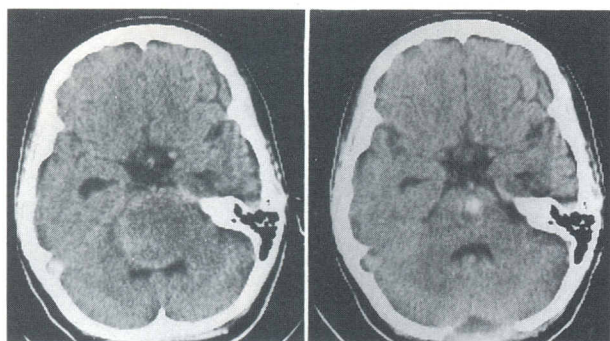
Left:* Preoperative computerized tomography (CT) scan with contrast enhancement. An isodense round, regular-shaped mass is seen intrinsic to the brain stem, with a fine ring of contrast enhancement. The fourth ventricle is partly obliterated due to bulging of the floor. *Right:* Postoperative CT scan without contrast enhancement obtained 7 days following surgery. The brain stem and fourth ventricle have resumed their normal shape. There is a small area of increased density within the hematoma cavity, which likely represents Oxycel packing filled with old blood clots.
